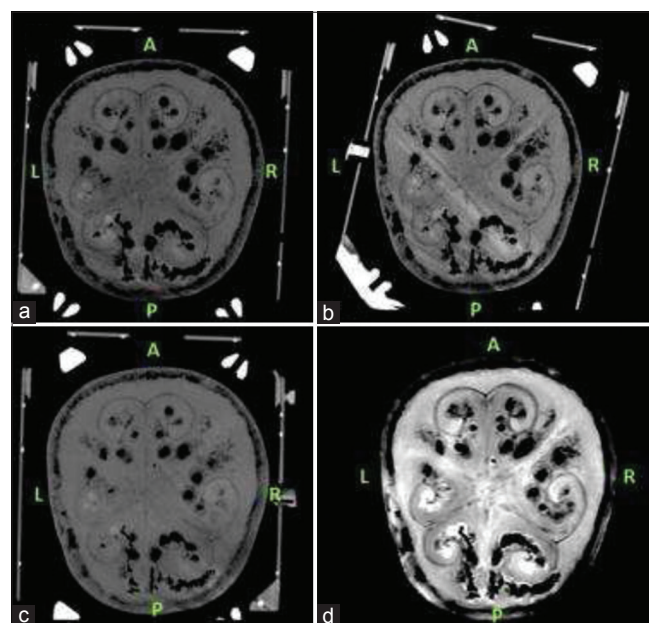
Stereotactic computed tomography slices for three scenarios (a) for Scenario 1, (b) for Scenario 2, and (c) for Scenario 3 at the target point and the T2-weighted axial magnetic resonance imaging scan slice at the same target point (d).
